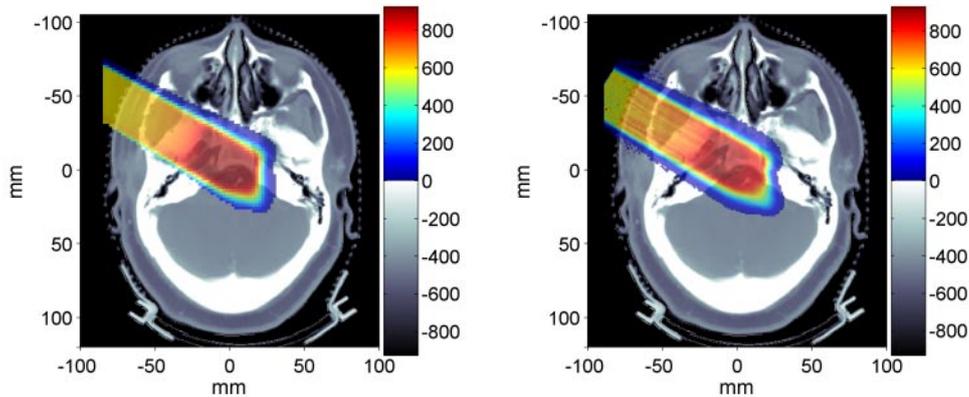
(Colour on-line) Comparison between treatment plan (left) and MC (right) calculated dose distributions for an oblique portal delivering 909 mGy to a clivus chordoma patient [20]. The color bar shows dose levels in mGy, whereas the CT numbers (black-white scale) were arbitrarily rescaled for display purposes.
